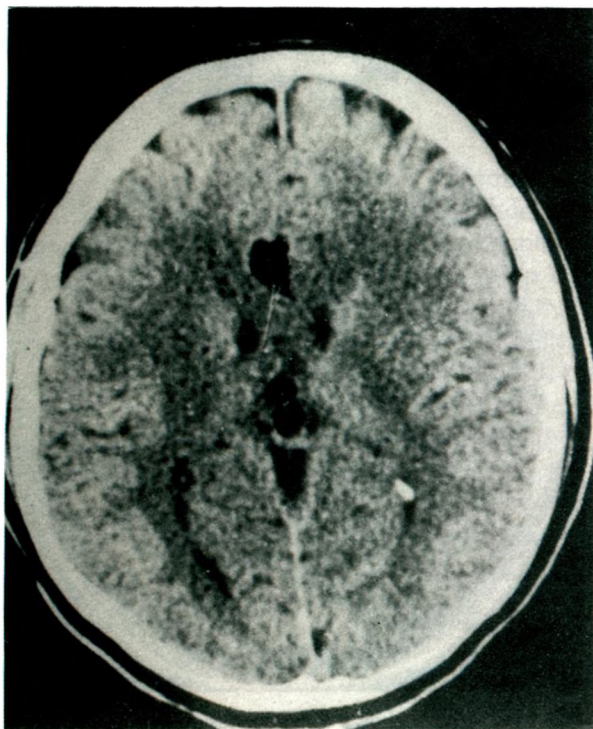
CT scan shows a hypodense region (-17.2 HU) at the left temporal pole.
